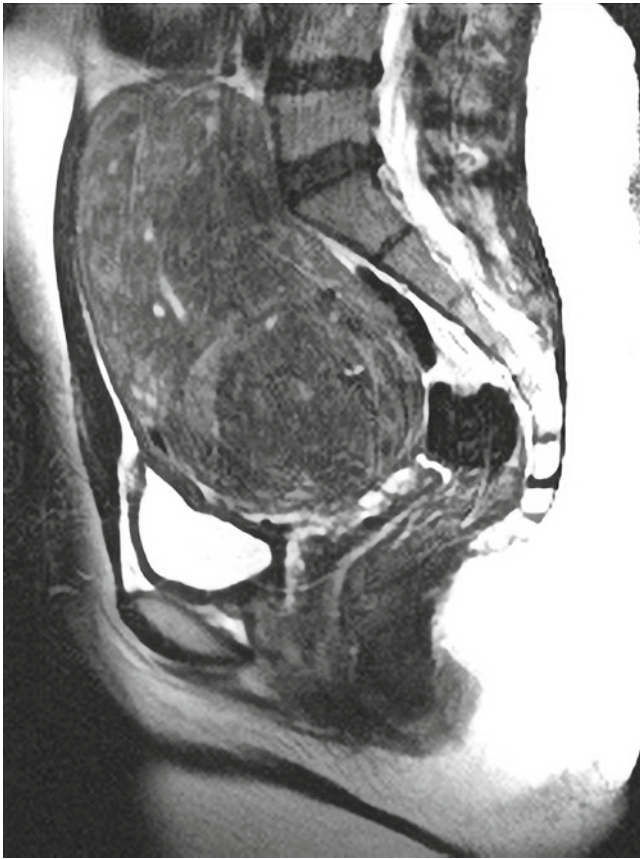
Diffuse adenomyosis. Sagittal T2-weighted image. Reproduced with permission from Magen A, Veniero JC. In: Hurd WW, Falcone T, eds. *Clinical reproductive medicine and surgery*. St. Louis, MO: Mosby/Elsevier; 2007. (Fig. 31.17 from 1st ed, part A only)
